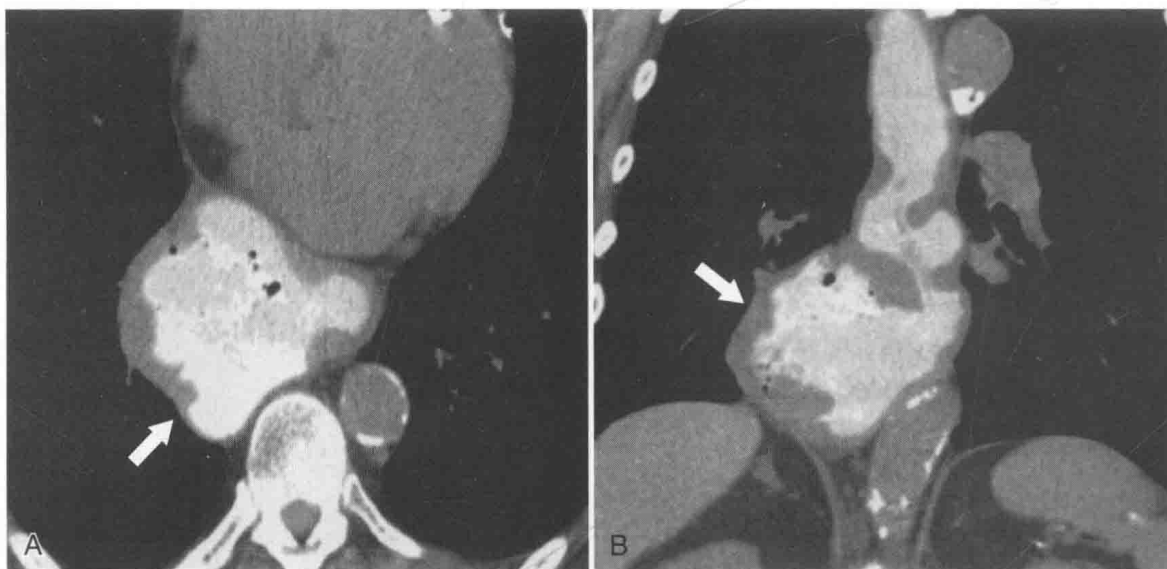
Axial (A) and coronal (B) CT in a 77-year-old man with a large, wide-mouthed (*arrow*) epiphrenic diverticulum.
